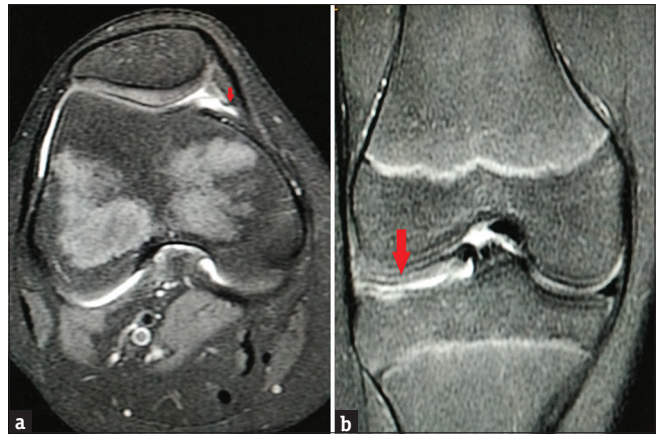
(a) Axial fat-sat spine-cho proton density magnetic resonance image of the right knee (3000/50) in a 14-year-old female demonstrating a cord-like elevation (arrow) in the medial synovial wall consistent with mediopatellar plica (Sakakibara type A). (b) Associated discoid lateral meniscus (arrow) in the same patient as in (a). Coronal fat-sat spine-cho proton density magnetic resonance image of the right knee (4136/50) demonstrating lateral meniscal body width of more than 15 mm with absent bow tie sign
